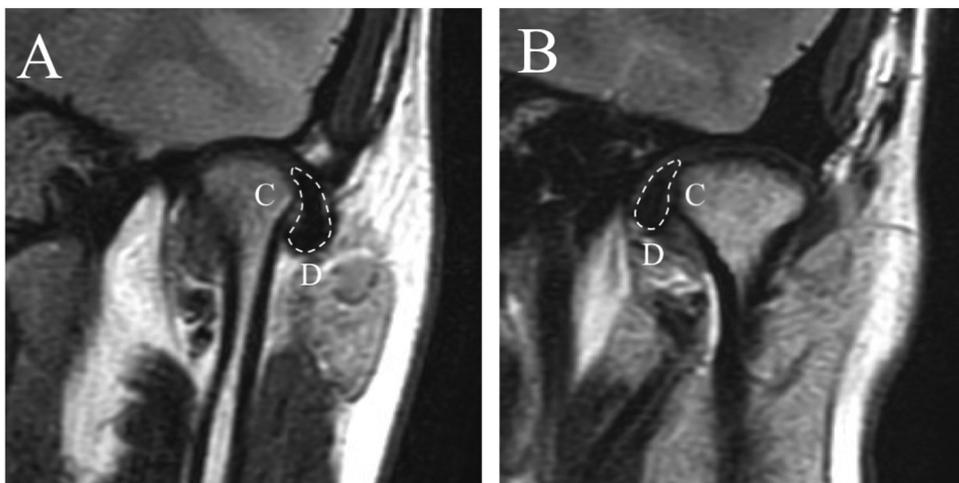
Classification of disc displacement under MRI examination: (A) coronal image showing anterolateral disc displacement, in which the lateral point of the disc (point D) is located below the lateral pole of the condyle (point C); (B) coronal image showing anteromedial disc displacement, in which the medial point of the disc (point D) is located below the medial pole of the condyle (point C).
